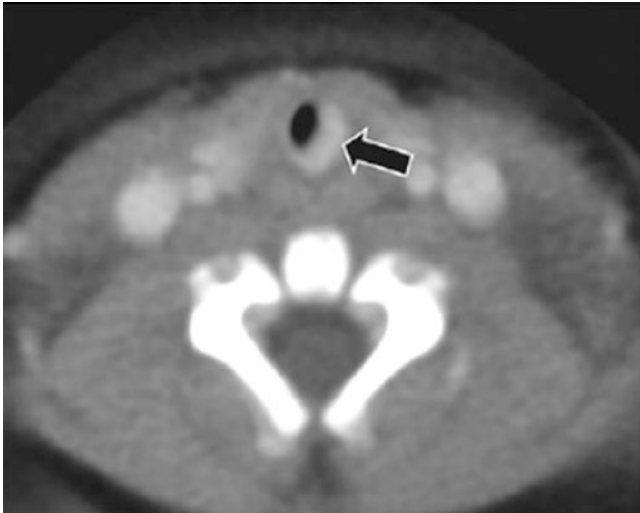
A 2-month-old girl who presented with increasing respiratory distress. Enhanced axial CT examination shows markedly enhancing subglottic lesion (*arrow*), consistent with subglottic hemangioma
